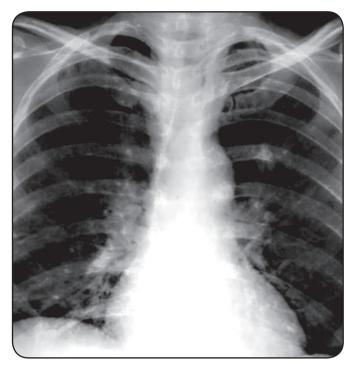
Routine anteroposterior chest X-ray after 10 days of treatment with ivermectin.
